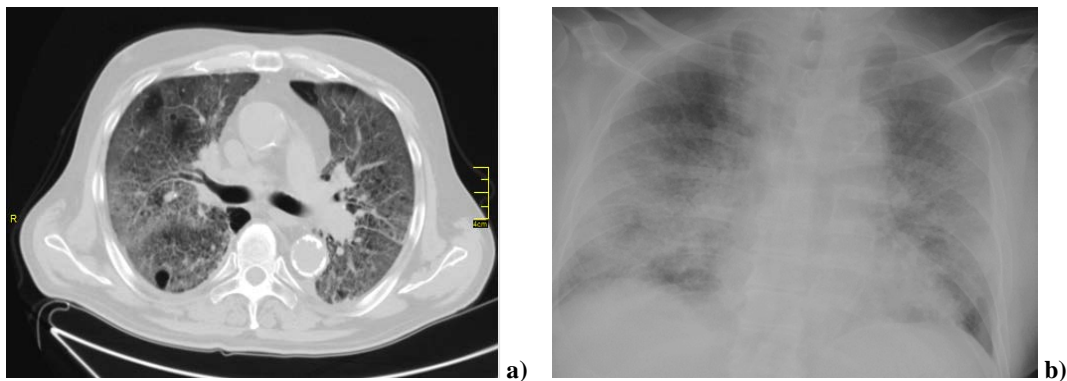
a) Computed tomography (CT) findings and b) Radiological findings in patients with lung cancer (LC) at the time of diagnosis of coronavirus disease 2019 (COVID-19): bilateral pneumonia in a 71-year-old male with stage IV non-small-cell LC treated with first-line cisplatin-based chemotherapy.
